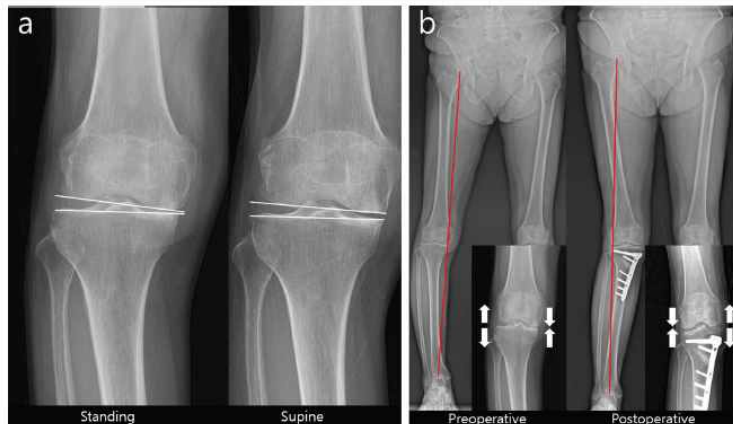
Perioperative change in the soft tissue tension around the knee. a Preoperative standing and supine knee radiographs. b Preoperative and postoperative scanogram. The difference of joint line convergence angle between weight-bearing and supine X-ray implies the possibility of soft tissue tension change after medial opening wedge high tibial osteotomy. The medial joint space is opened, and the lateral joint space is closed by shifting the weight-bearing axis after medial opening wedge high tibial osteotomy. This results in unexpected overcorrection
